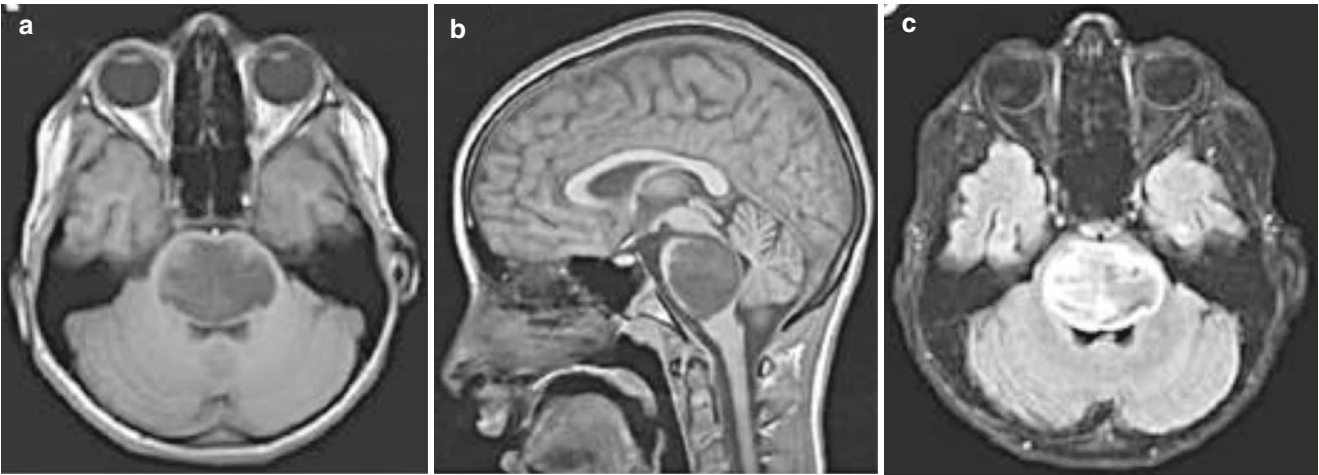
Typical appearance of magnetic resonance imaging scans of a patient with a diffuse brainstem glioma. (a and b) T1-weighted axial and sagittal images without contrast. (c) Axial fluid-attenuated inversion
